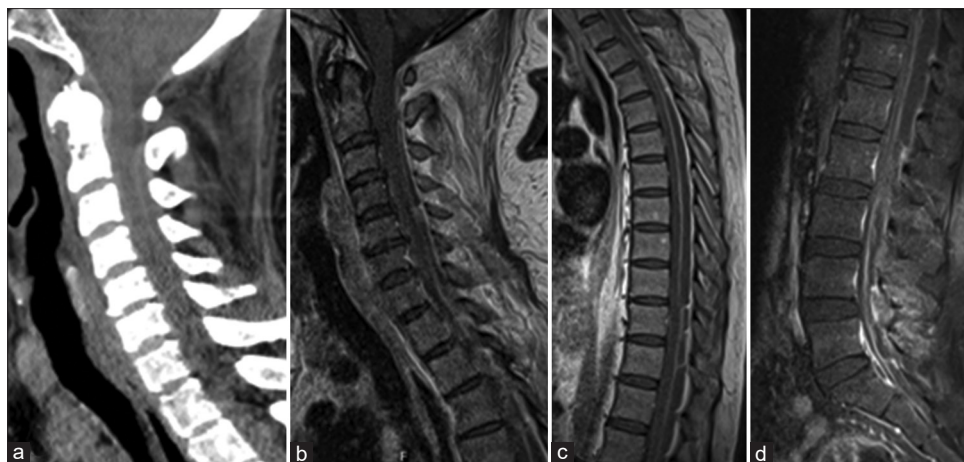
(a) Noncontrast computed tomography scan showing a posterior epidural collection, (b-d) All-spine contrast-enhanced magnetic resonance imaging showing very extensive epidural empyema, encompassing all segments of the spine. Mass effect is particularly pronounced in the thoracolumbar segments
